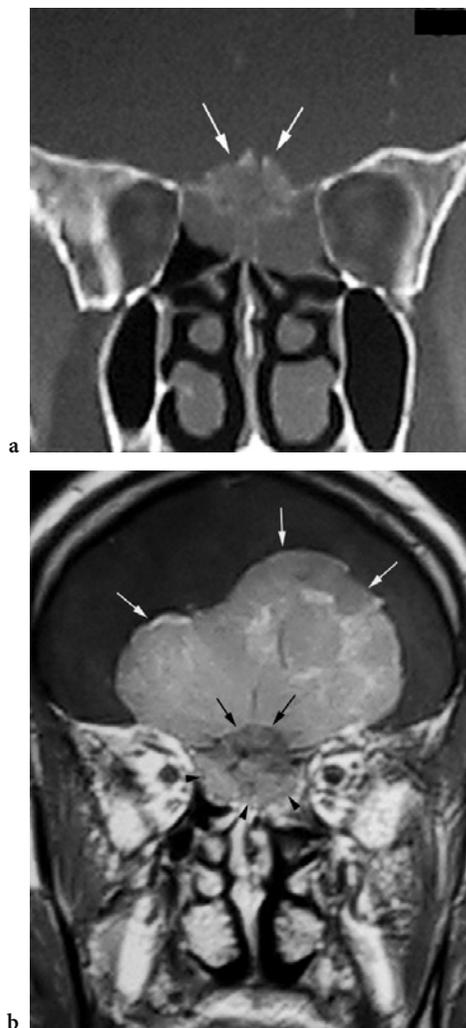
Meningioma of the planum sphenoidale in a 60 years old male who complained anosmia, visual acuity loss and mental changes. a Coronal CT shows a large olfactory groove meningioma with *blistering* of the bone toward the inner cranium (*white arrow* on a, *black arrow* on b) and invasion of the ethmoid. b On postcontrast coronal T1-weighted image, both the intracranial (*white arrows*) and extra-cranial (*black arrowheads*) components remarkably enhance. Bone blistering at the olfactory groove is hypointense than the surrounding soft component
